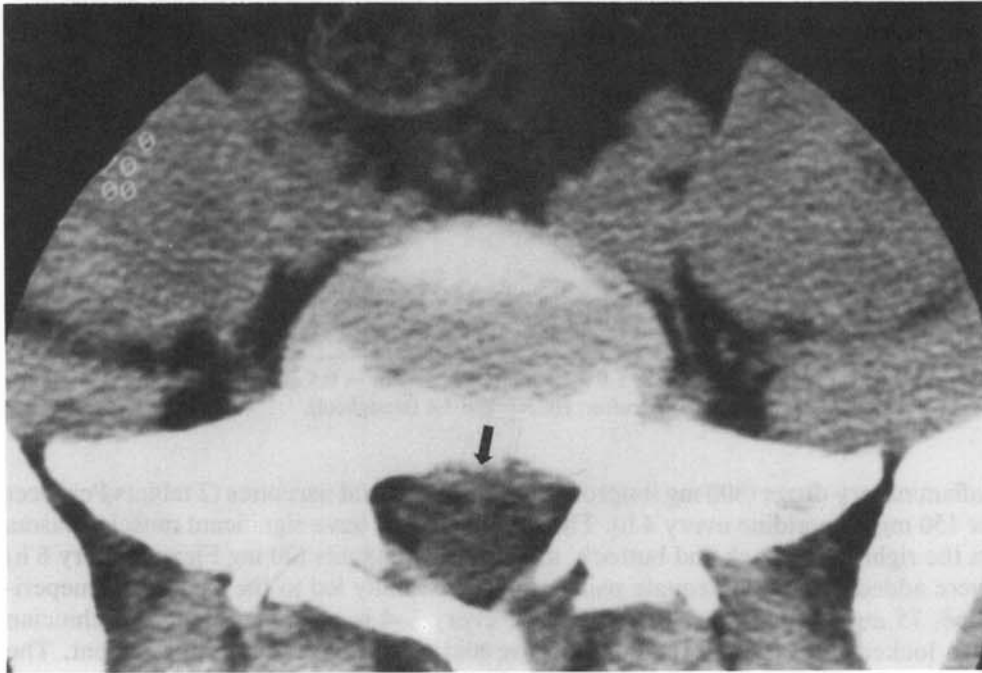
Representative image from the CT scan of case 1. Note the midline herniation of the L5-S1 intervertebral disk (arrow).
